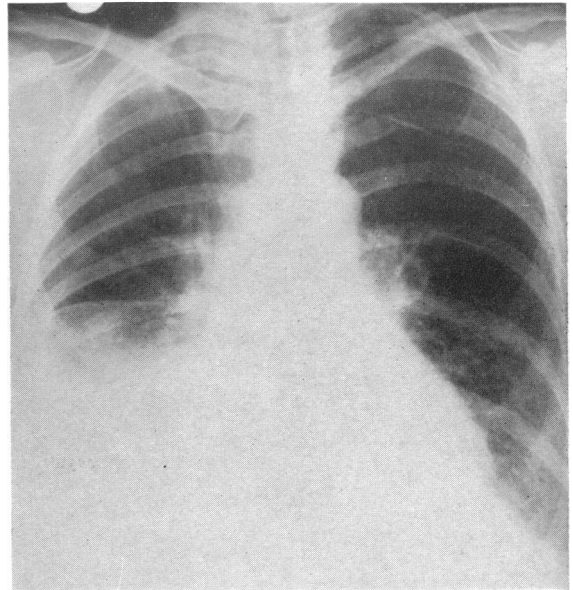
Six-foot postero-anterior radiograph of chest in Case 2, showing generalized cardiac enlargement and right pleural effusion.
